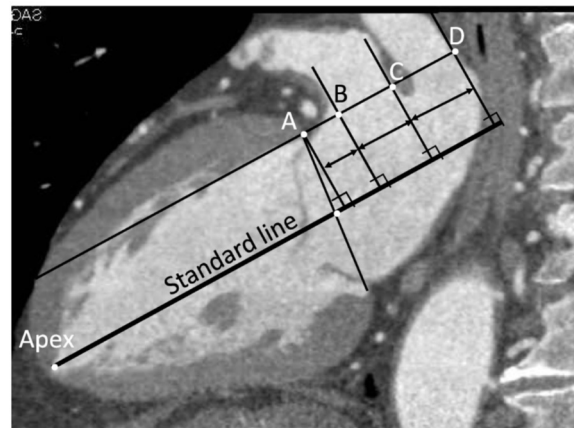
Definition of four distinct points (A to D) on sagittal section of multi-detector CT
